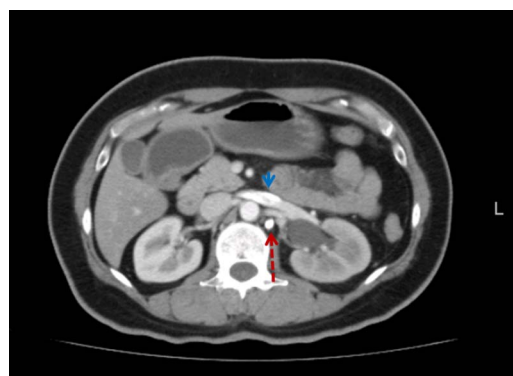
CT scan axial view showing increased contrast density in the hemiazygous (broken arrow) and renal vein (small arrow).
